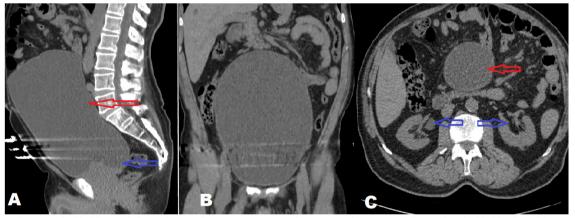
A. Sagittal view of the bladder on abdominal CT (red arrow). Approximately 5 cm of pelvic saging is observed at the bladder floor (blue arrow). B. Coronal view of the bladder on abdominal CT. C. Transverse sections of the abdominal CT show the bladder dome (red arrow) reaching the renal pelvis (blue arrow) level CT: Computed tomography
